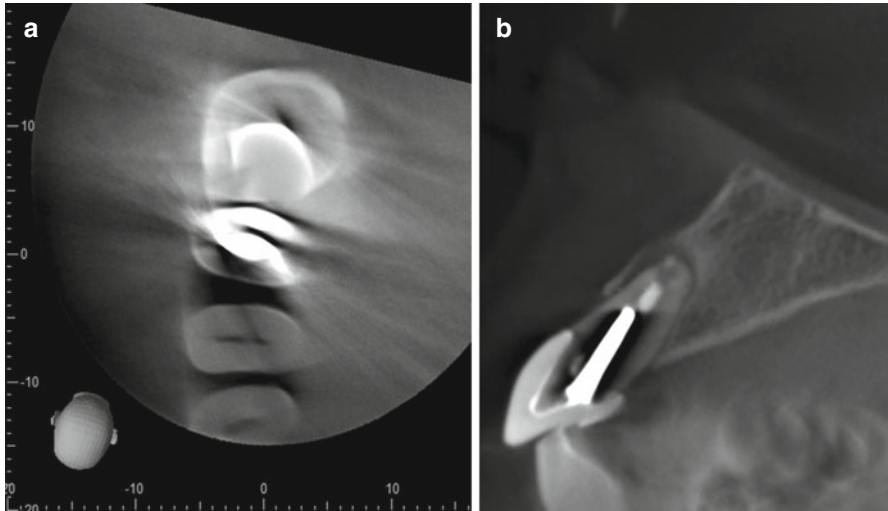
(a) Axial slice demonstrating metallic restorations in the second premolar and first molar teeth. Note the radiating pattern of dark bands and streaks. Note how linear artifacts are evident on the root of the adjacent first premolar. (b) Sagittal CBCT section through the maxillary central incisor. Note the dark zone around the metallic post
